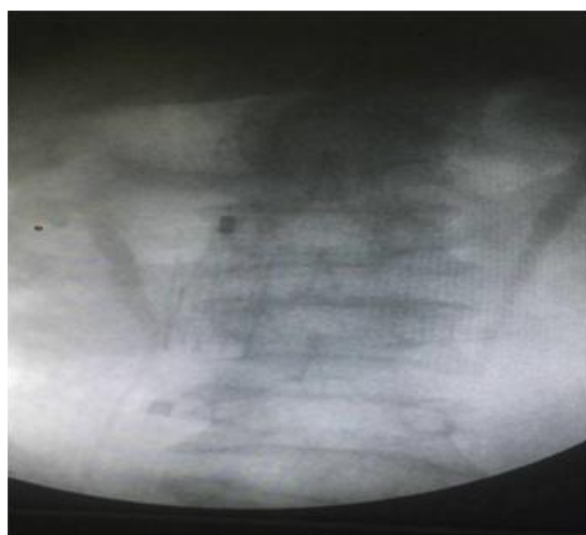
The seventh postoperative day X-ray abdominal plain radiograph: Position of the filter (without tilt, shift) and its opening.
